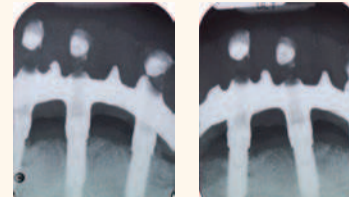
Post-op radiographs at 3 months after therapy.
